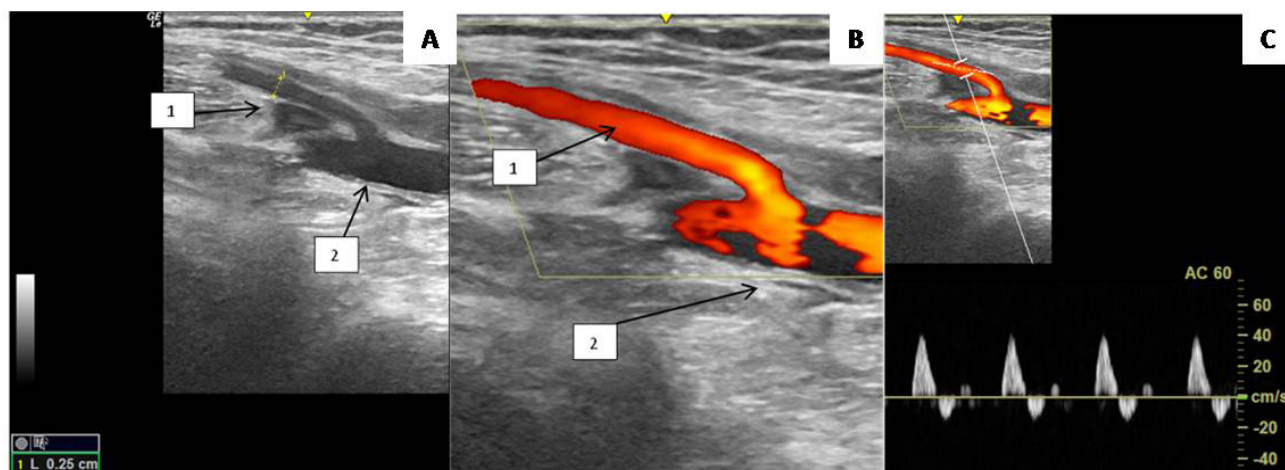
Duplex scan of the sural artery; (A) B-mode; (B) Color Doppler mapping mode; (C) Spectral Dopplerography mode.
